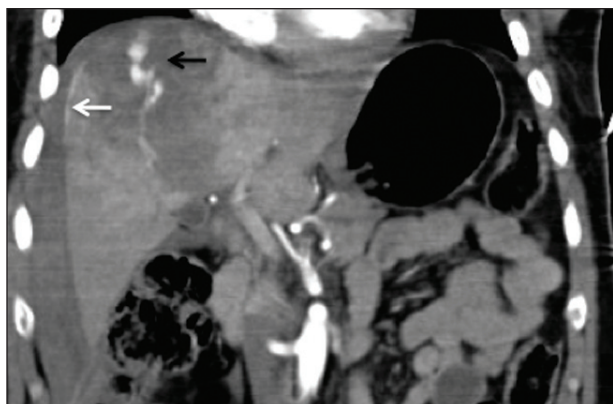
CT of the abdomen with coronal reconstruction showing an irregular area of contrast enhancement (black arrow), which is associated with contrast material extending into the subcapsular space (white arrow). These findings are consistent with contrast material extravasation and represent ongoing bleeding.
